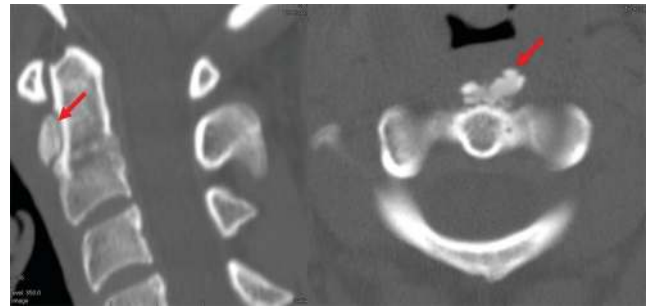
Computed tomography of the cervical spine: presence of calcification in the anterior region of C2 (sagittal and axial sections, respectively). Source: personal archive.
